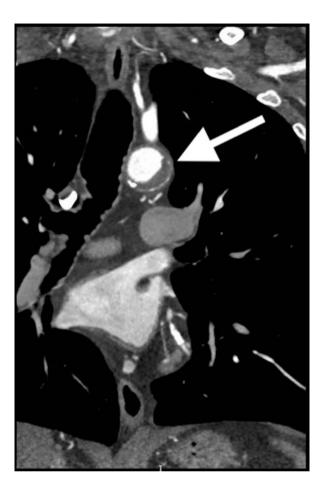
CT angiography coronal projection of the same intramural hematoma
